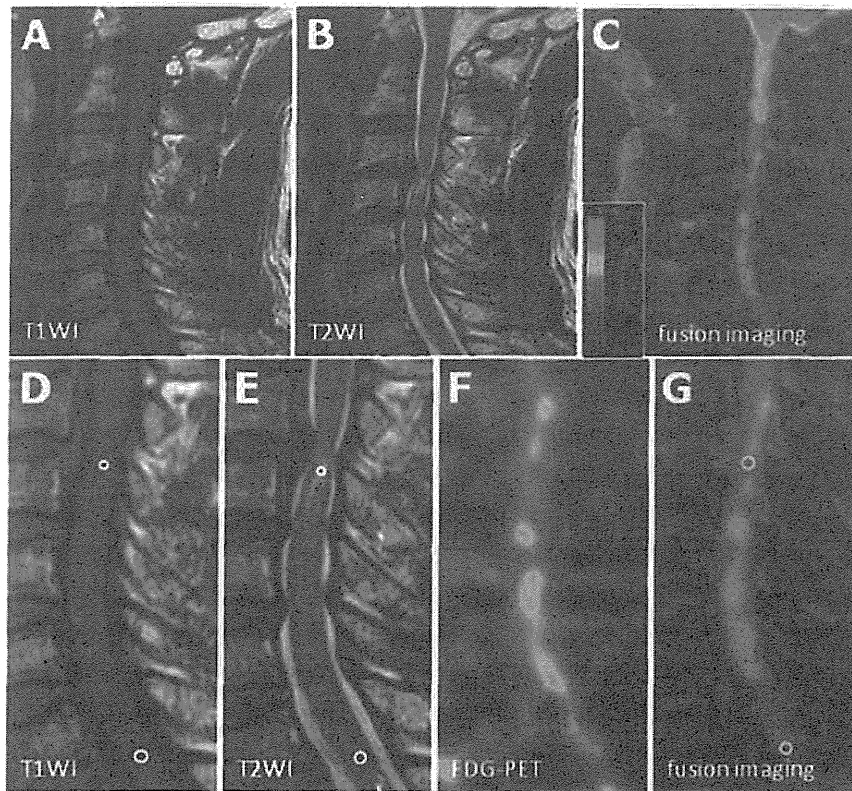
A 62-year-old man with cervical spondylotic myelopathy was treated surgically and showed a poor neurological improvement rate of 28.6 % at follow-up. (a) Midsagittal T1-weighted MRI, (b) midsagittal T2-weighted MRI, (c) MRI/PET fusion imaging (d, e), (f) ^{18}F -FDG PET sagittal image, and (g) MRI/PET fusion sagittal slice demonstrate inconspicuous ^{18}F -FDG uptake at the level of lesion with increased signal intensity (Reprinted, with permission, from [29])
